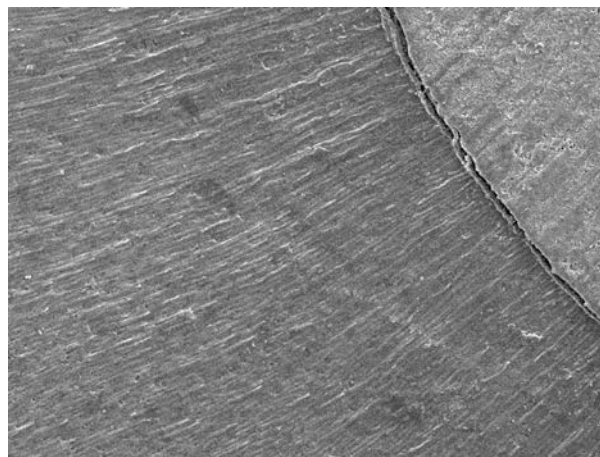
Group 3: resin tags (G2 Bond) formation after ultrasonic activation (SEM x1200).
